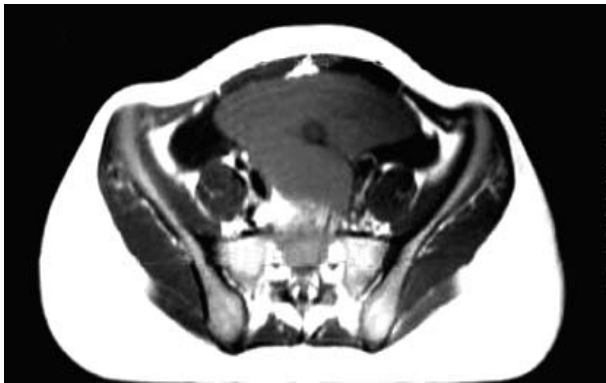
Axial T1-weighted magnetic resonance image of the pelvis showing the wandering spleen.
